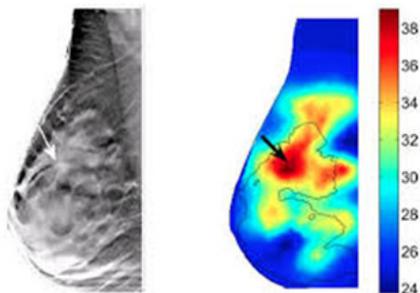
An optical imaging technique help to reduce the number of unnecessary biopsies in breast cancer screening. As shown on the right, the technique reveals the hemoglobin concentrations associated with the formation and growth of tumors. A scan with the X-ray-based technique digital breast tomosynthesis is shown on the left. The arrow in each image points to the 2-cm invasive carcinoma in the breast. Adapted from Athinoula A. Martinos Center for Biomedical imaging - Optical imaging could lead to fewer biopsies in breast cancer screening by Gary Boas February 9, 2015.<sup>[59]</sup>
